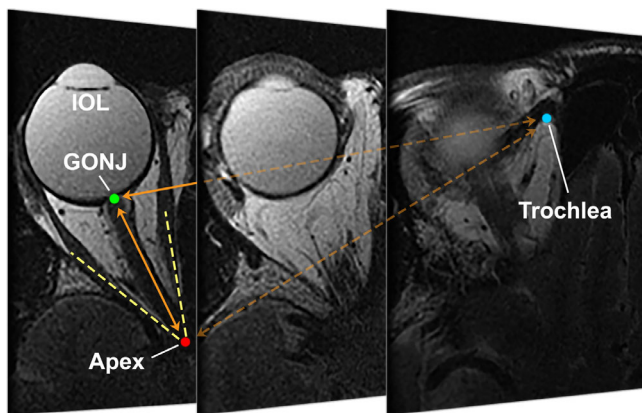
Axial MRI of representative orbit in pseudophakic subject, with contiguous 2 mm thick image planes arranged from inferior at mid-globe at left, to superior at right with the plane including the trochlea. GONJ, globe-optic nerve junction; IOL, intraocular lens.
